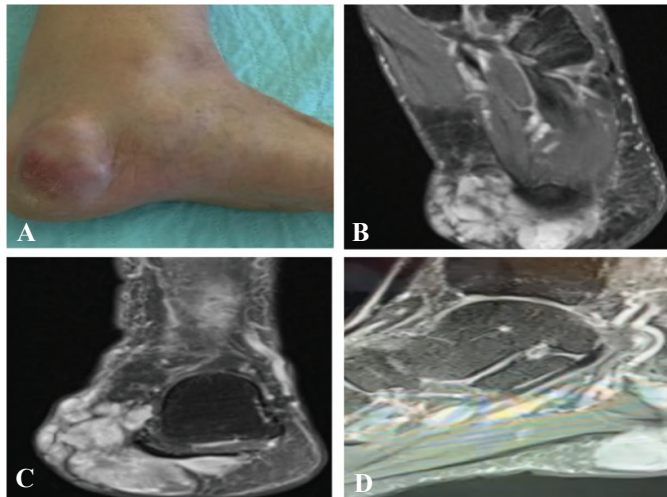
Clinical examination of A) hard, tender, and oval mass, B) axial, C) coronal, and D) sagittal Magnetic Resonance Imaging projections of the lesion
